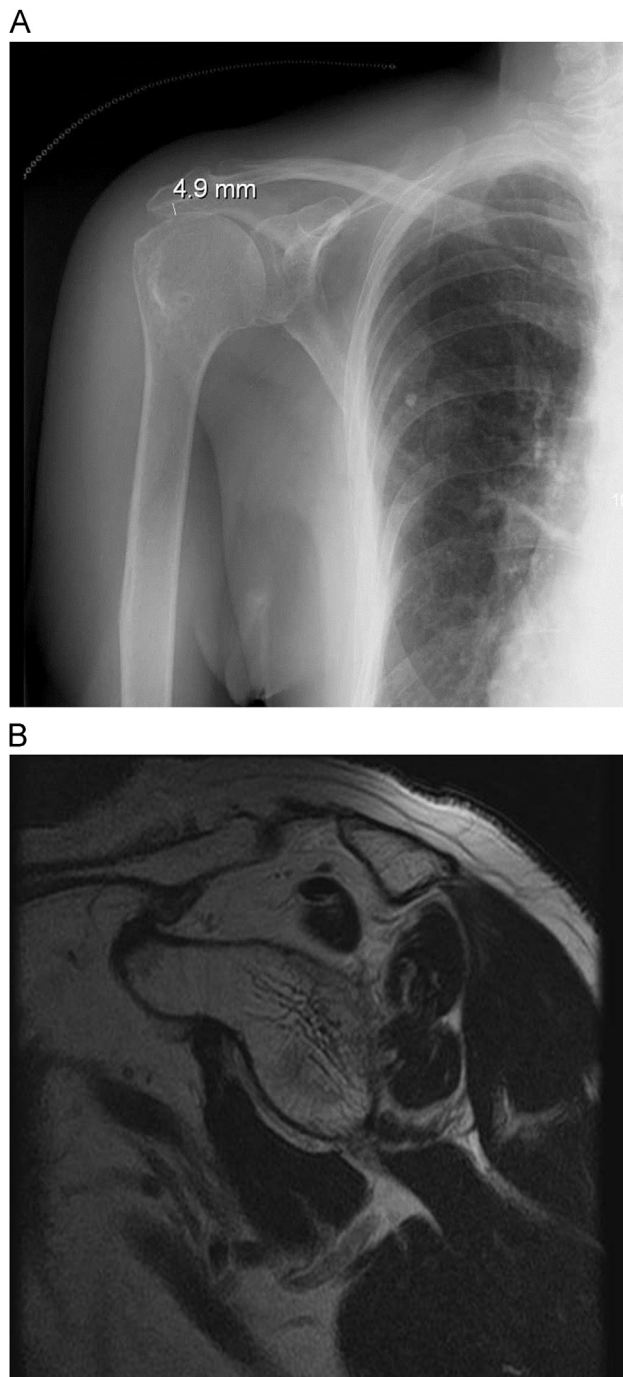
An AP radiograph showing decreased AHD with corresponding fatty atrophy of the supraspinatus on MRI.
